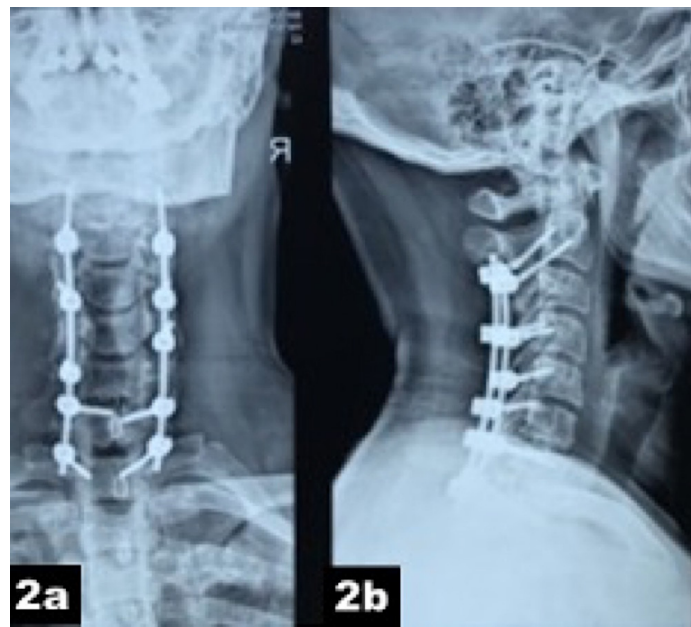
Postoperative AP and lateral cervical X-ray: (a & b) showing C3 to C6 laminectomy and C2 to T1 screw rod fixation
